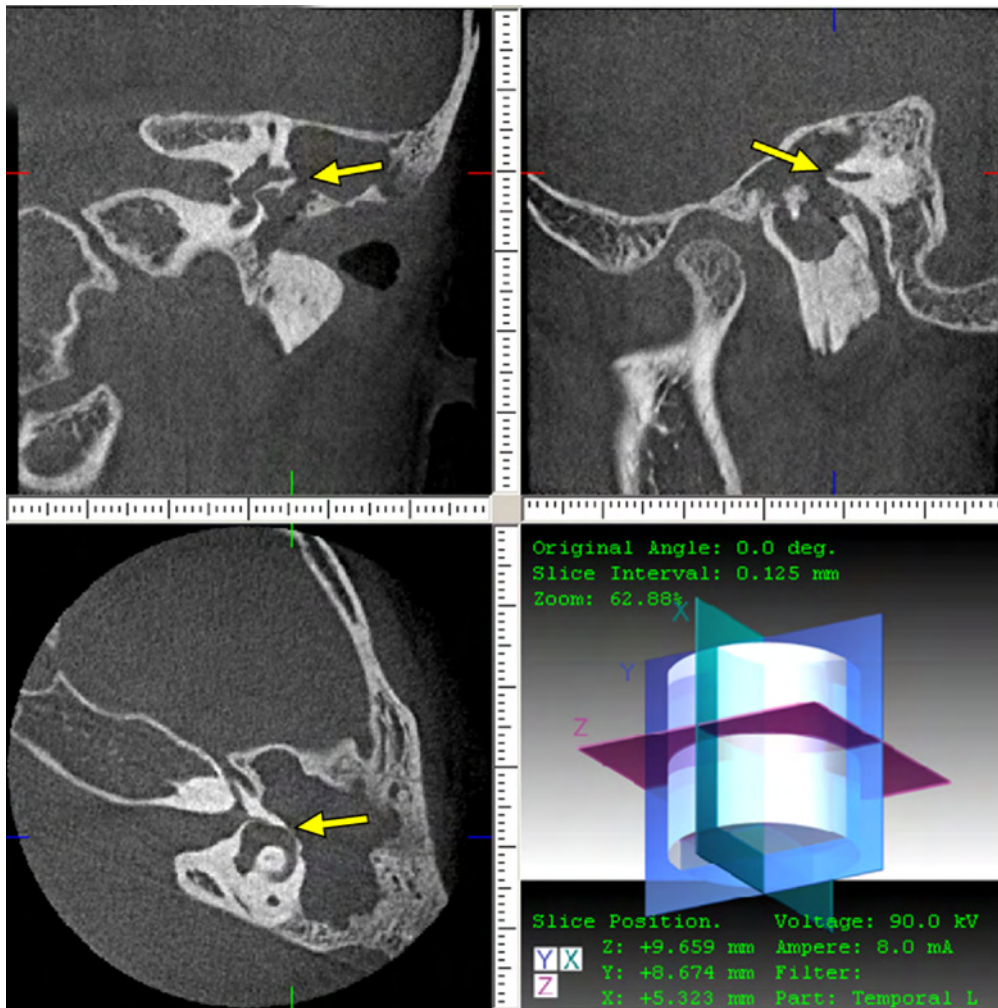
Pre-operative CBCT scan, showing erosion of the otic capsule with lateral semicircular canal fistula.
